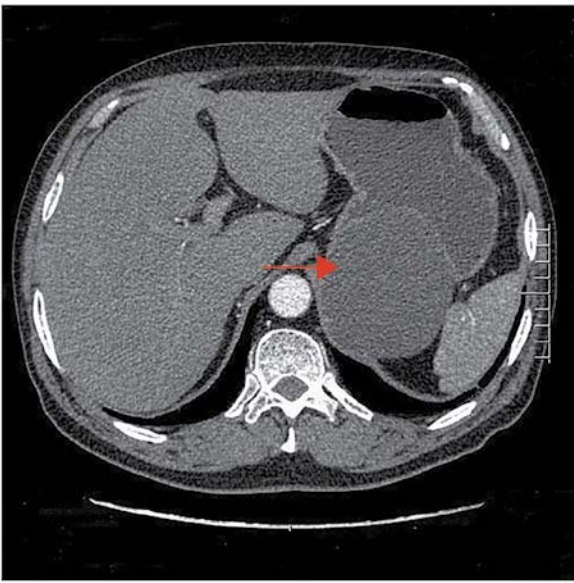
CT image displaying cystic lesion between the spleen and stomach (red arrow).
